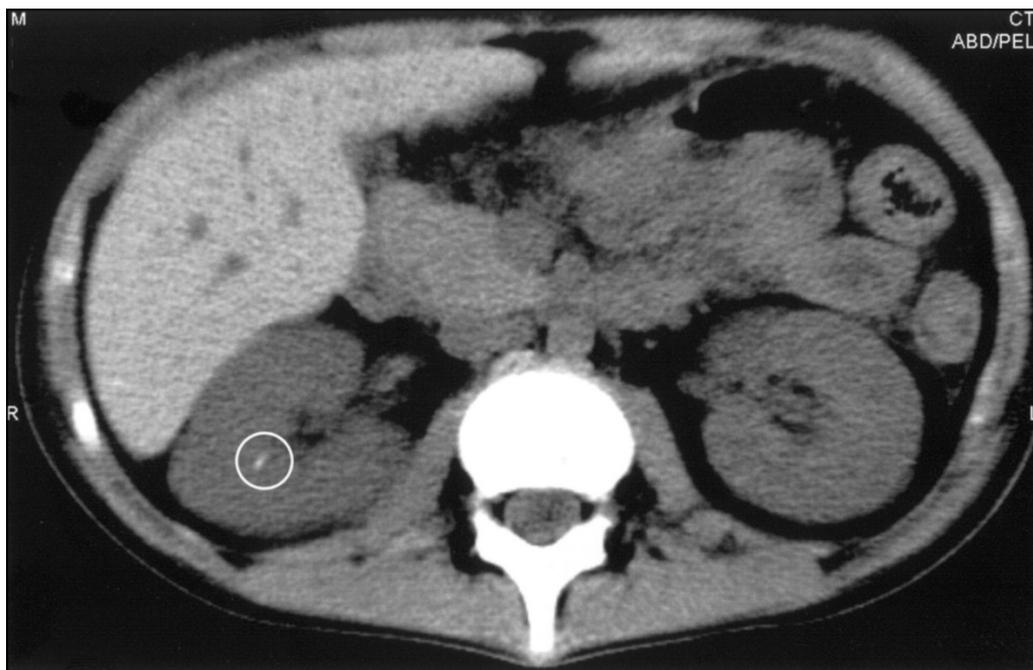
Renal calculus on unenhanced computed tomography (CT)*
